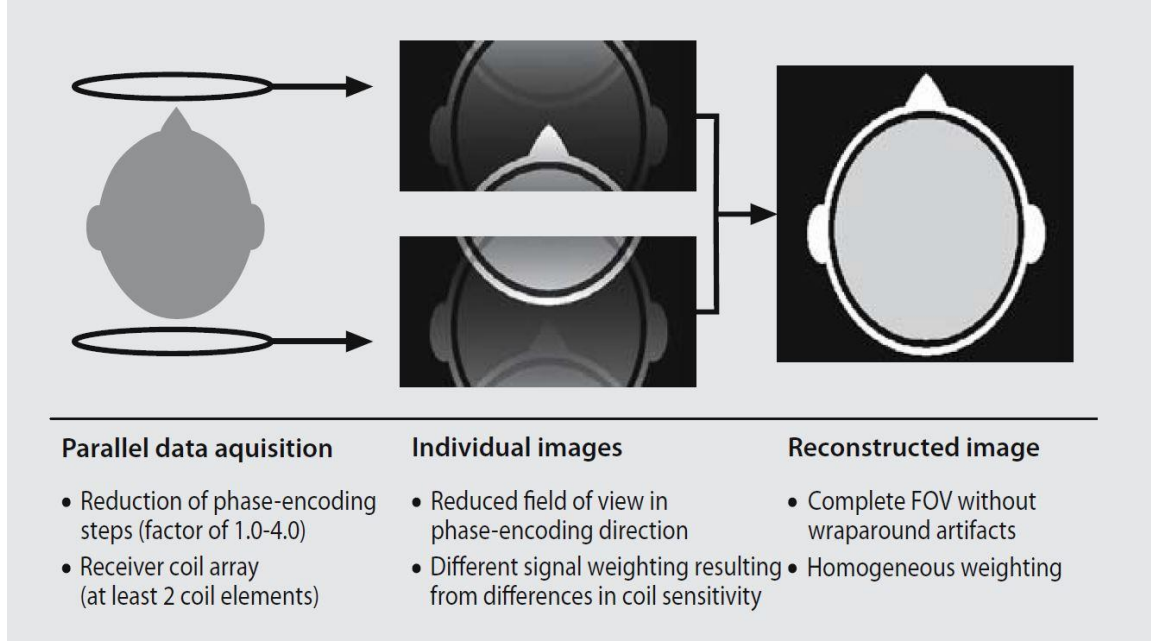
In parallel imaging, an array of receiver coils simultaneously collects the MR signals. Scan time is shortened by reducing the number of phase-encoding steps. As a result, the individual images are obtained with a smaller FOV and show the typical wraparound artifacts. A complete image without wraparound artifacts is reconstructed by combining the individual images. Reproduced from Weishaupt D, Köchli VD, Marincek B: How Does MRI Work? 2008.
